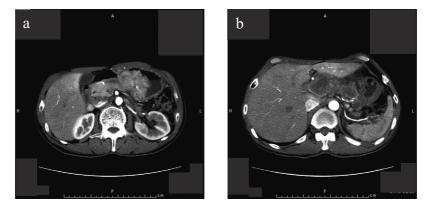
Abdominal computed tomography (CT) findings of the patient. CT revealed a mass in the lesser curvature of the gastric antrum (a) and enlarged lymph nodes (b).
